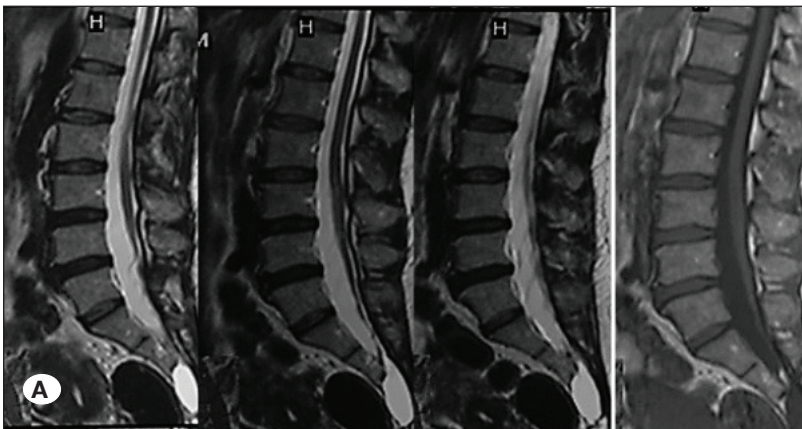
A) A 21 year-old female patient, complaining of pain and numbness in the lower back and legs. T2W and T1W sagittal MRI show that the spinal cord ends L4-5 levels B) Leg pain gone and back pain and numbness reduced. T2W and T1W sagittal MRI show that the spinal cord untethered.
